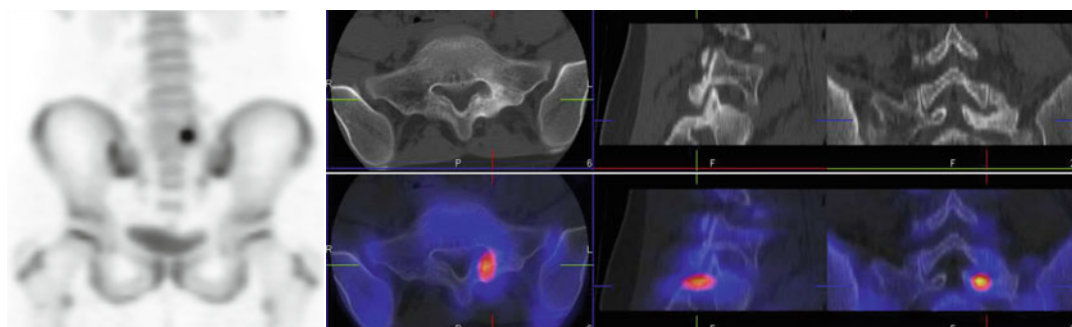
Stress changes in the pars interarticularis. *Left:* MIP of the pelvis. *Right:* ^{18}F -NaF PET and CT fusion. Selected slices reveal intense fluoride uptake in the region of the right L5 pars. On CT, there is a linear defect through the right L5 pars interarticularis
